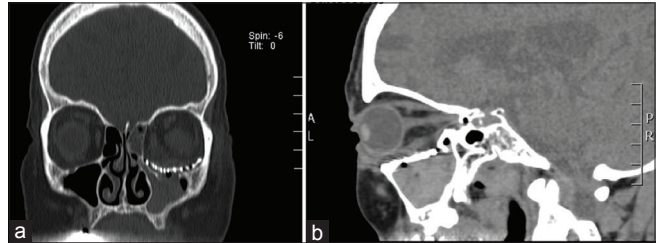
(a) Postoperative computed tomography image with a coronal section with orbital floor reconstruction, (b) sagittal view of the reconstruction
